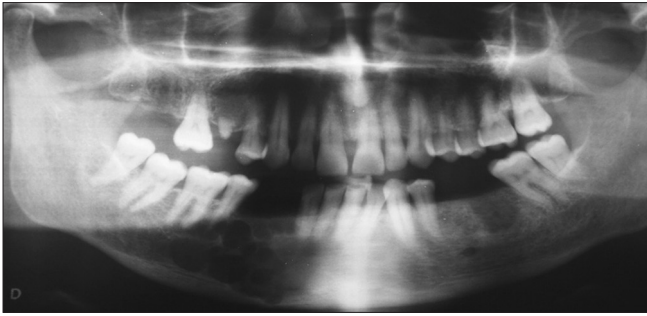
Preoperative dental X-ray. Typical ameloblastoma features are reported on the right side of the mandible
